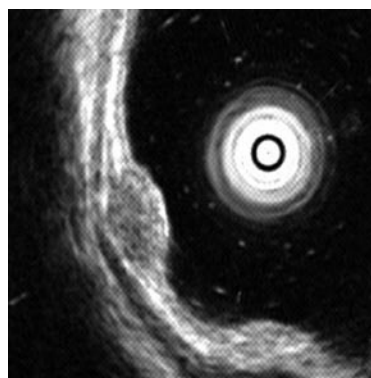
Endoscopic ultrasonography demonstrating a hypoechoic solid tumor in the superficial submucosa without involvement of the muscularis propria.
